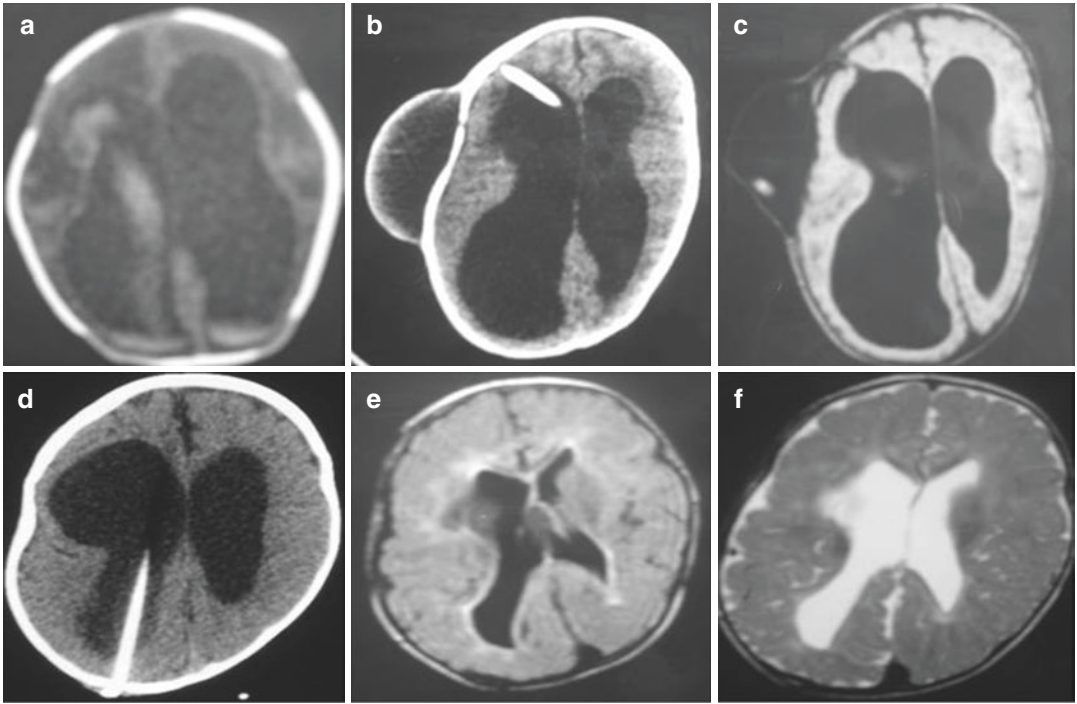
Premature posthemorrhagic hydrocephaly in CT scan of 30th pregnancy month (a). Hydrocephaly was decreased after ventriculosubgaleal shunt (b, c). CT scan demonstrates a ventriculoperitoneal shunt 3 months after
